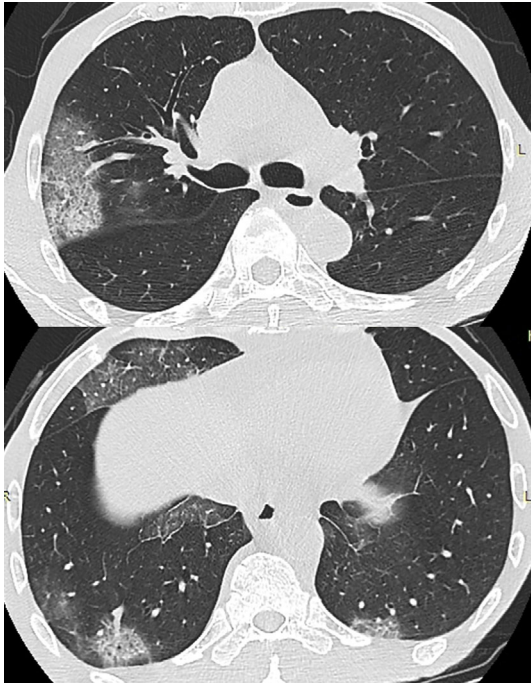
Chest CT findings in Case 1. Case 1 was positive for rhinovirus. High-resolution CT of the lung shows peripheral ground-glass opacity in the right upper lung with smooth interlobular septal thickening. Multiple patchy ground-glass opacities are also observed.
